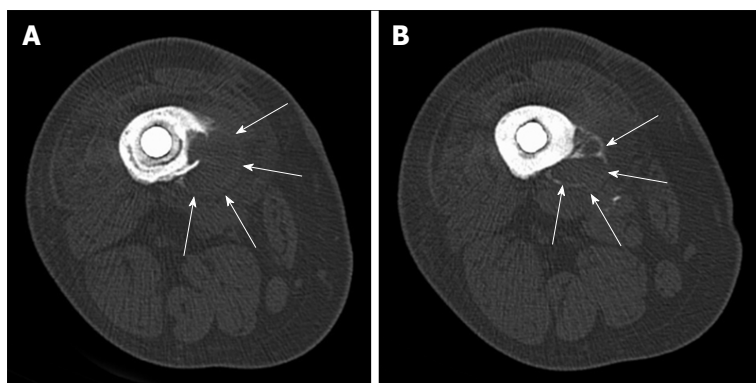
Transverse computed tomography scan images of distal femoral diaphysis centered over lytic lesion. A: Image shows a surrounding soft tissue mass of 2.8 cm. Erosive lytic lesion extends down to the inner cortex. Also note the radiolucent lines between the prosthetic implant and cement mantle, as well as the radiolucent line between the cement mantle and bone; B: Demonstrates septation of the soft tissue mass with peripheral calcification (arrows). This is typically a worrisome sign for a neoplastic process.
